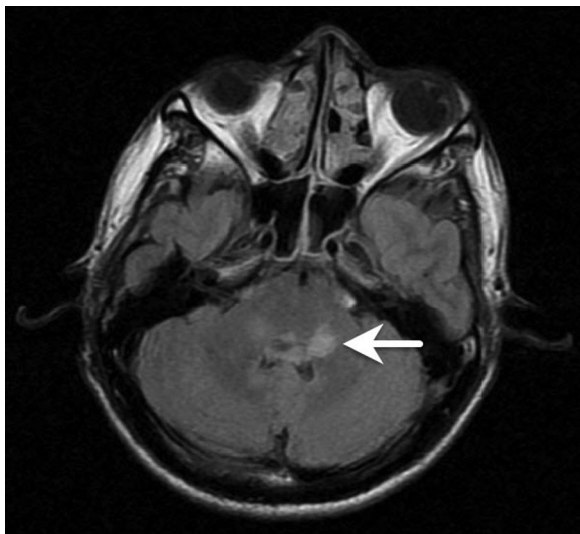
Axial Flair weighted brain MRI in January 2020. The demyelinated area in the vestibular nucleus is shown.
